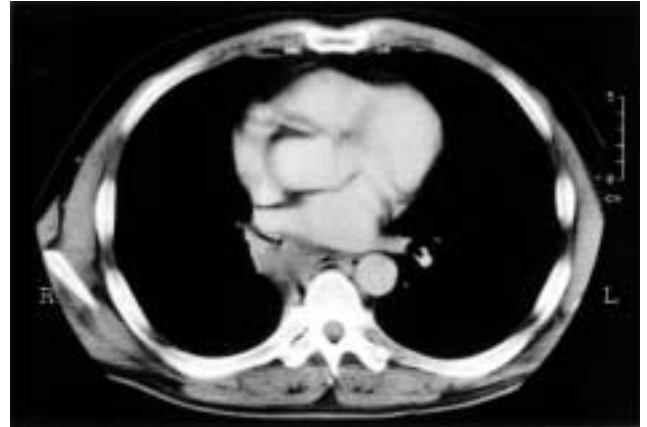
Chest CT scan (Case 2).
